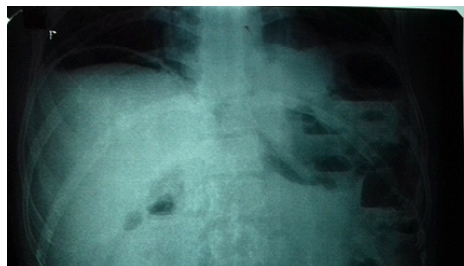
Erect chest radiograph on the day of admission showing gas under right dome of diaphragm.
